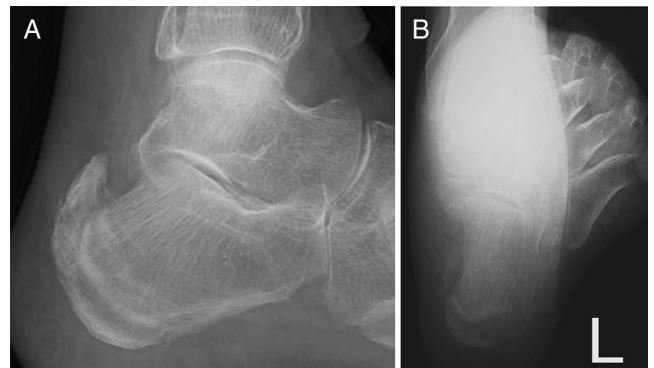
Plain (A) lateral and (B) axial radiographs showing a type 1 Beavis fracture.
